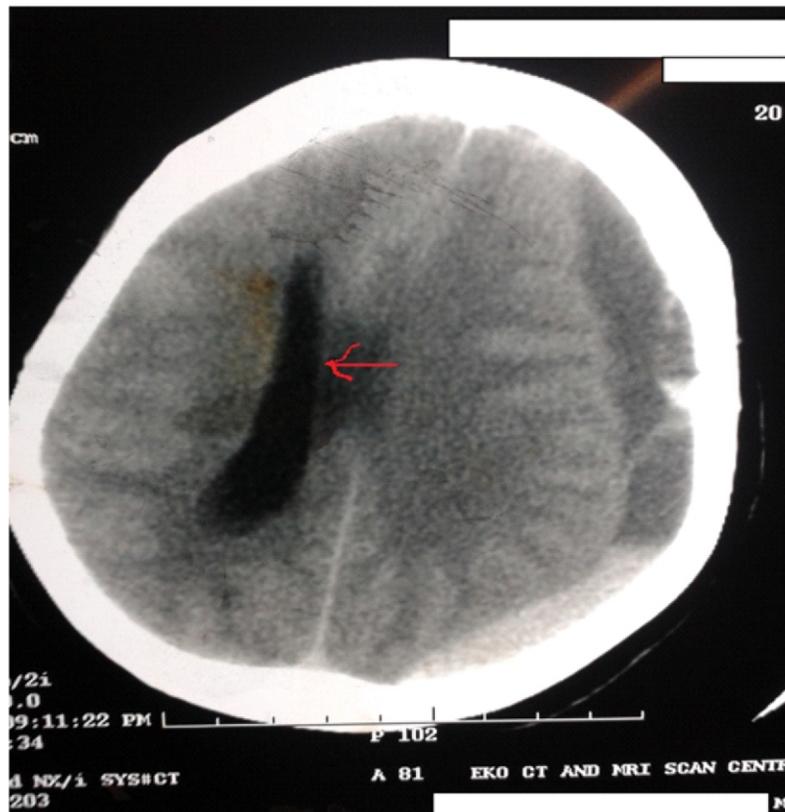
Computed Tomographic scan of brain showing the left sided SDH with midline shift (arrow)
